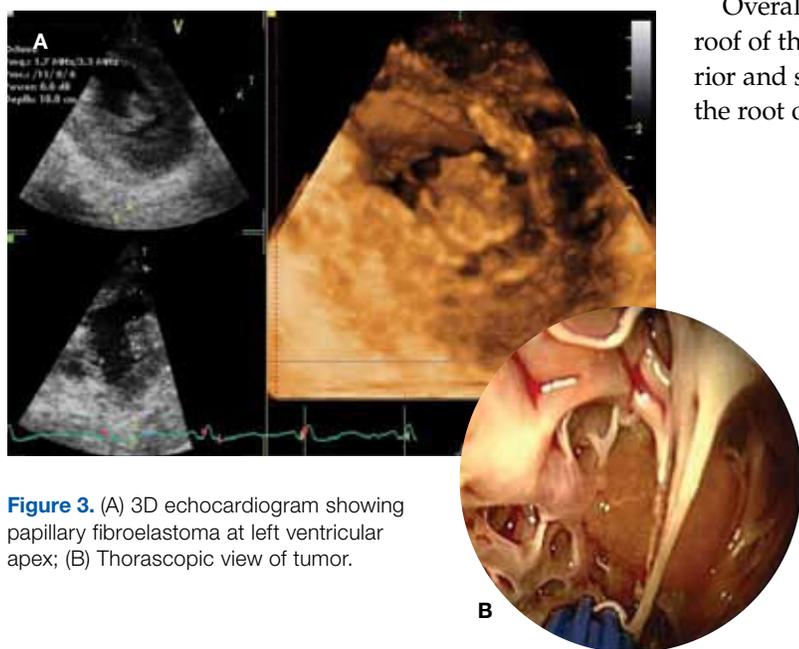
(A) 3D echocardiogram showing papillary fibroelastoma at left ventricular apex; (B) Thorascopic view of tumor.
